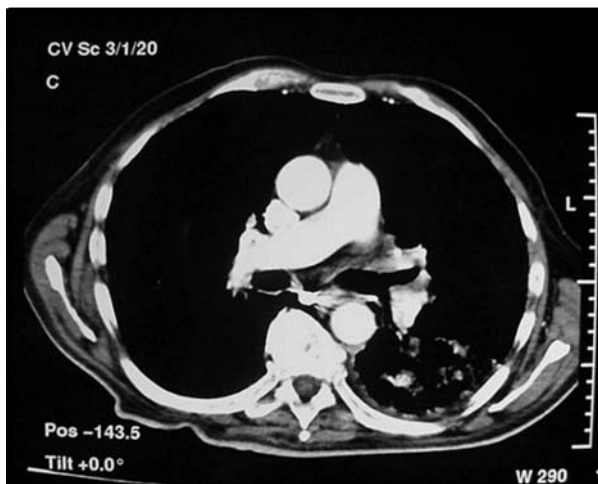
high resolution chest CT scan, with pulmonary mass on the left lower lobe and mediastinal lymphadenopathy.
